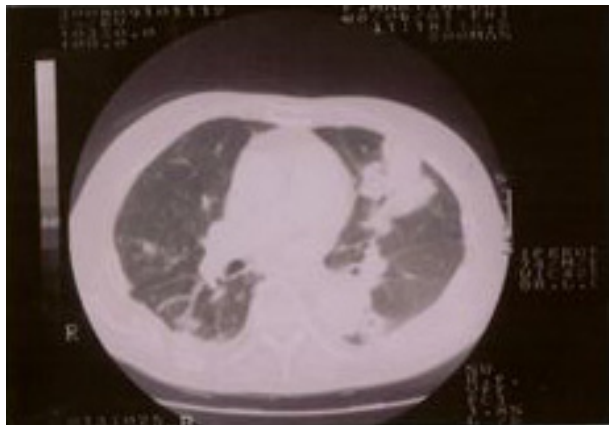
CT scan of the chest showing multiple nodules and consolidation throughout both lungs.
